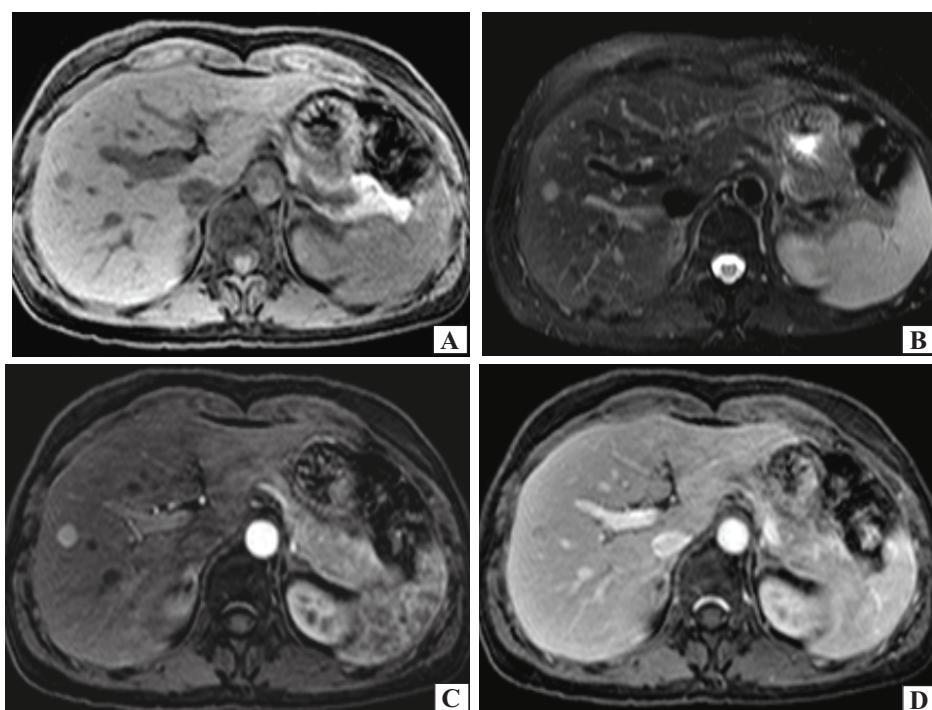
MRI of beta-catenin-mutated HA in a 35-year-old male. Male sex is characteristic for this subtype of HA.
